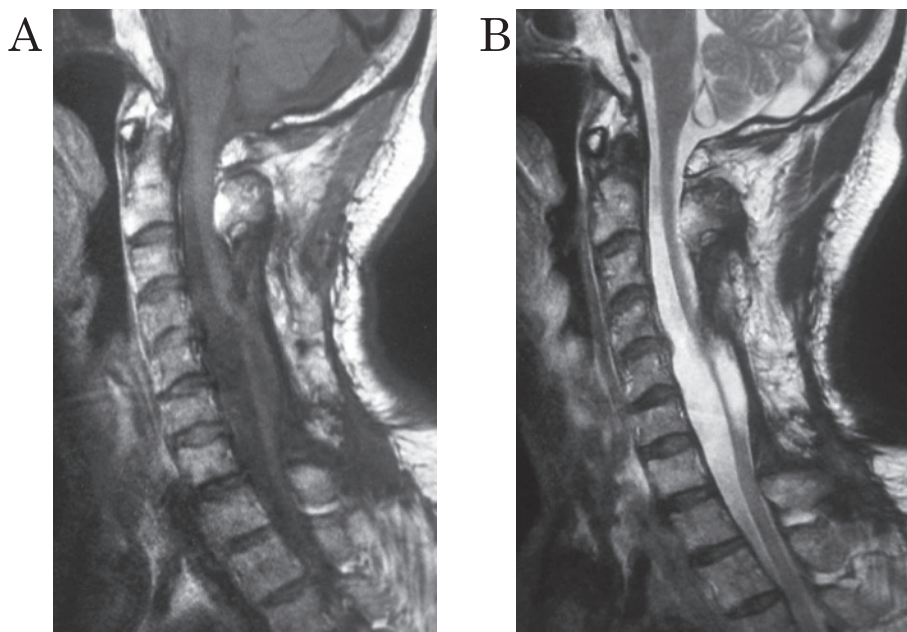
Postoperative sagittal T1-weighted (A) and T2-weighted (B) images showing the absence of a residual tumor at the present time.
